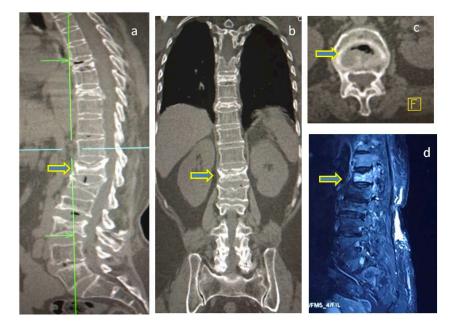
CT scan showing the intervertebral cleft in sagittal, coronal (a, b- arrow) and vaccum in axial cuts (c-arrow). Fat suppressed MRI showing the affected vertebrae with patchy edema.
